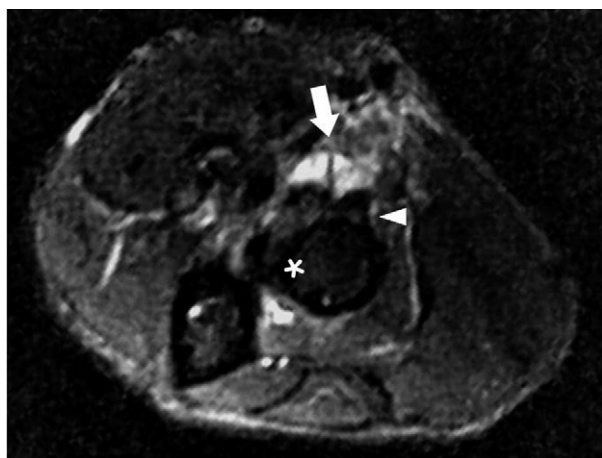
T2-weighted axial magnetic resonance imaging through the elbow shows the tumor (arrowhead) arising from lateral to the radial tuberosity (asterisk) and peritendinous fluid collection (arrow) around the tumor.
